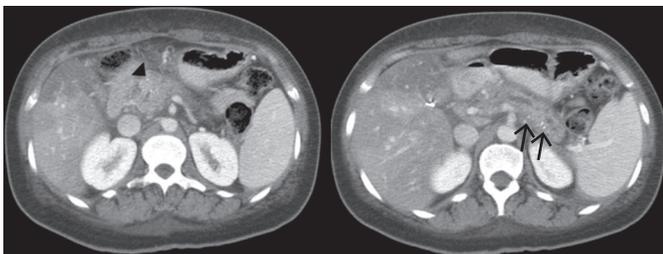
Contrast-enhanced axial CT imaging from 2008 (age 32) showing punctate intraductal calculi (arrow head) and few punctate pancreatic parenchymal calcifications (arrow).
